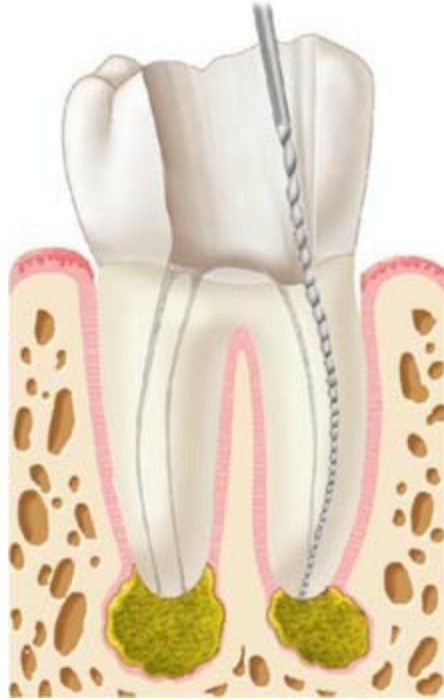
A small K-file negotiates the canal to its terminus. An apex locator or radiograph is used to confirm the file's position.
